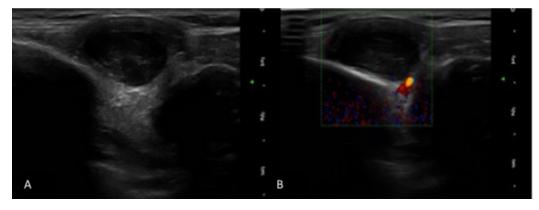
Ultrasound of the swelling showing a hypoechoic soft-tissue mass surrounding the clavicle (A) without inner vascular signal on color Doppler imaging (B).
